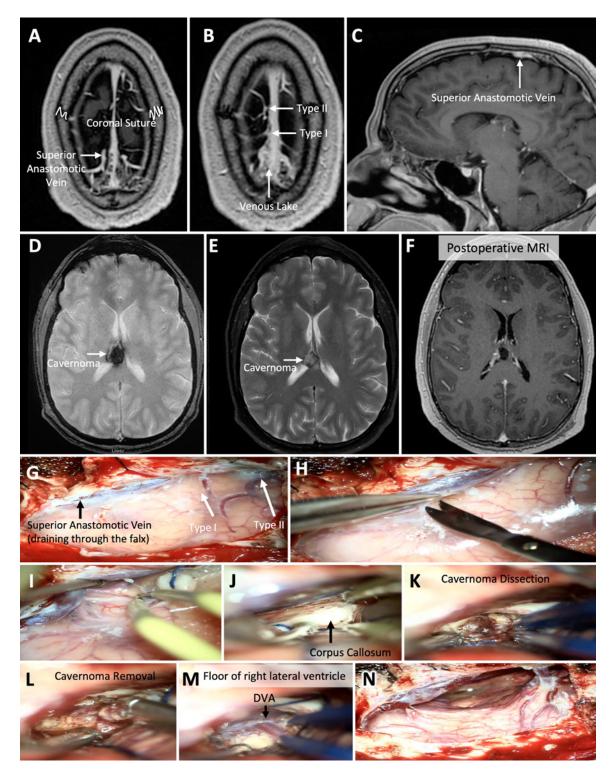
Type 1 and 2 case examples in a 41-year-old male. Preoperative postcontrast axial (A and B) and sagittal (C) T1-weighted MR images showing type 1 (I) and 2 (II) venous configurations posterior to the coronal suture (*squiggly lines*), with a large venous lake and a large superior anastomotic vein of Trolard draining into the SSS indirectly through the falx. Preoperative gradient echo (D) and T2-weighted (E) sequences show a cavernous malformation in the right lateral ventricle attached to the forniceal commissure and undersurface of the corpus callosum. Postoperative postcontrast T1-weighted MR image (F) shows complete resection of the cavernous malformation after a parietal central craniotomy and interhemispheric approach. Intraoperative photographs show a stepwise interhemispheric approach for resection of a right lateral ventricle cavernous malformation in the setting of a challenging superior anastomotic vein draining into the SSS by first traveling through the falx (G) with type 1 and 2 venous configurations in proximity, making up for an initially very narrow surgical corridor. The arachnoid is first sharply (H) and bluntly (I) dissected to unterher the right cerebral hemispheric so that gravity maintains the interhemispheric fissure open with the aid of small cotton patties. The cingulate gyri are detached, and the pericallosal arteries are mobilized, laterally exposing the corpus callosum (J). FIG. 3. (*continued*) \rightarrow
